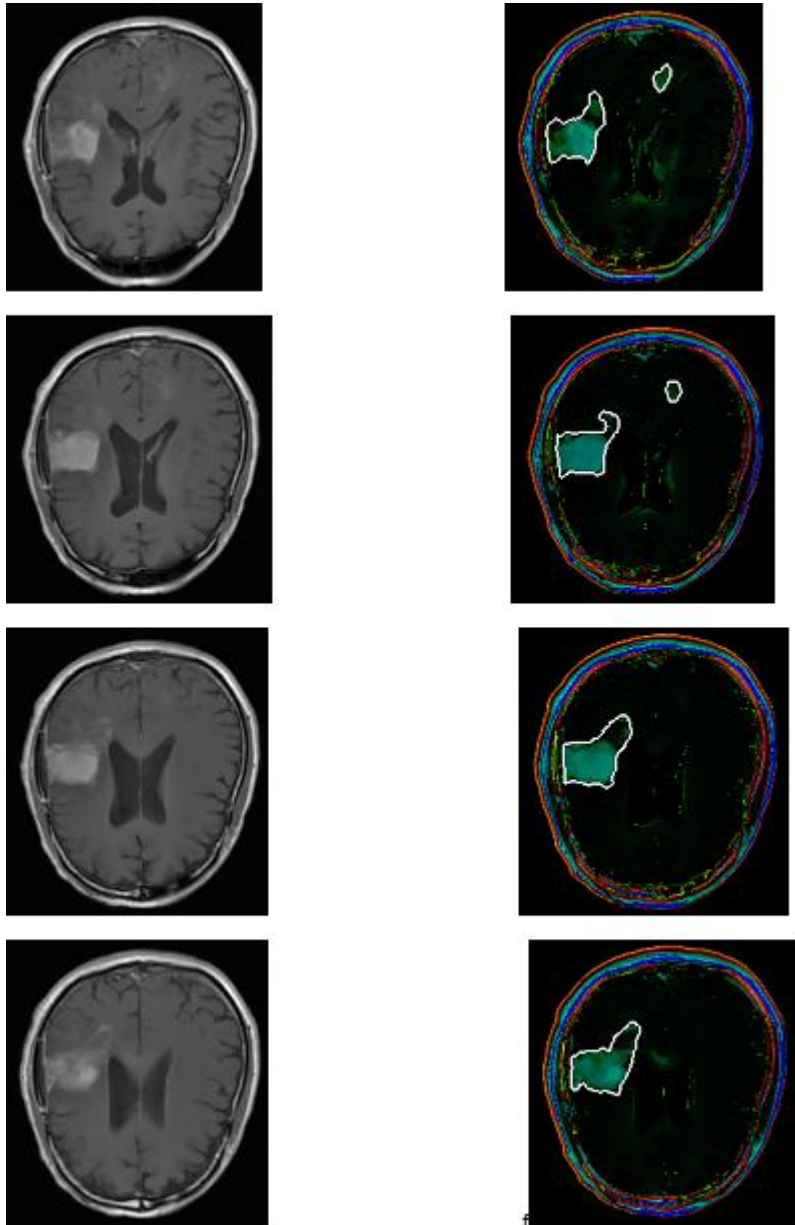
Brain tumor detection results: original T1-W MR image (1st column) and the respective signature maps generated using the proposed scheme (2nd column). White lines are delineations from the radiologist used as the gold standard.
